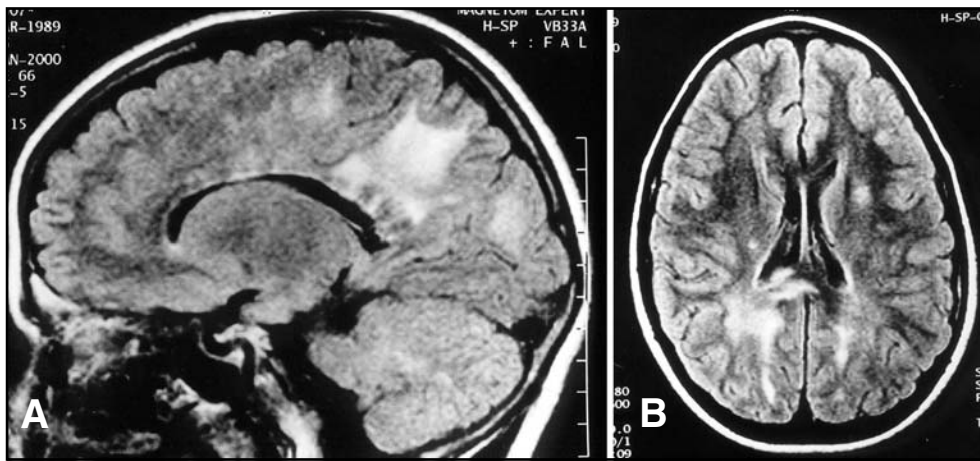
Sagittal Fast-FLAIR MRI scan shows multiple hyperintense lesions, some of them coalescent, in the periventricular white matter extending to the pericallosum region, with minimal mass effect. B. Axial Fast-FLAIR brain images shows several hyperintense white matter lesions, in the corona radiata and corpus callosum splenium.
